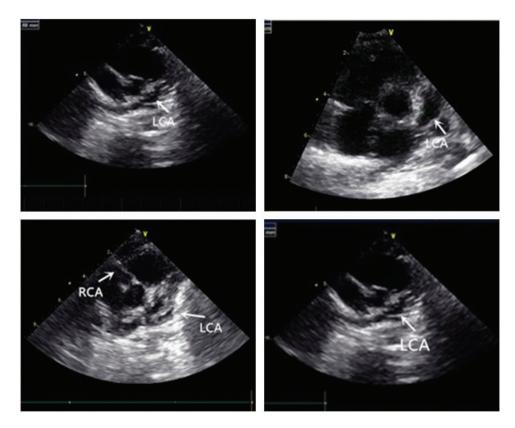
Echocardiography of the patient. Echocardiography shows aneurysmal dilatation of the bilateral coronary arteries. The maximal diameter of the left coronary artery (LCA) reached 5.5 mm and that of the right coronary artery (RCA) reached 6.2 mm
